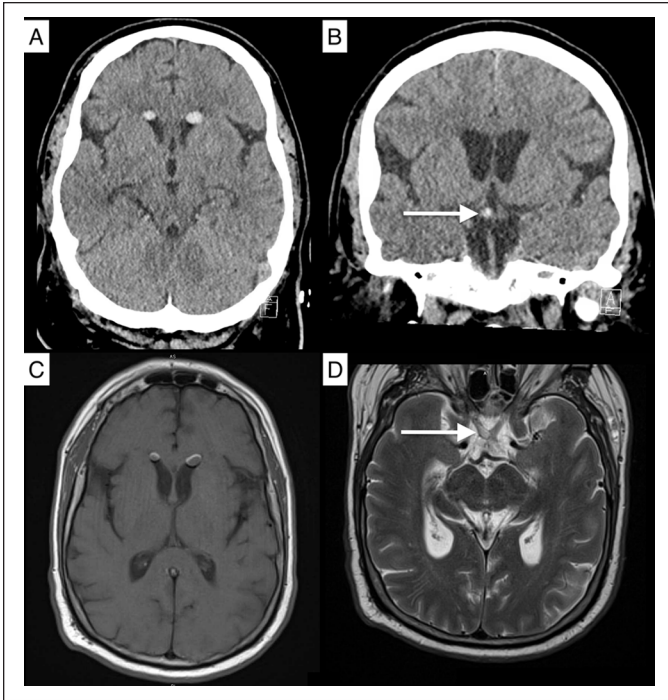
Neuroimaging at index presentation, 31 months postoperatively. (A) Computed tomography of the brain in supine positioning with axial slices shows bilateral ovoid hyperdensities consistent with silicone oil (SO) migration to the anterior horns of both lateral ventricles, with an average density of 85 Hounsfield units. (B) Additional hyperdensities are found in the right side of the optic chiasm. There is no evidence of hydrocephalus, cerebrospinal fluid outflow obstruction, or intracranial mass effect. (C) Magnetic resonance imaging (MRI) of the brain with gadolinium contrast in supine positioning. Axial slices in the T1-weighted sequence show well-circumscribed ovoid structures of intermediate signal in the anterior horns of both lateral ventricles. The right-sided lesion measures 4.7×4.6 mm axially. The left-sided lesion measures 5.8×9 mm axially. (D) Noncontrast T2-weighted MRI shows similar intensity lesions noted within the right optic nerve with obliteration of the subarachnoid space sheath and the right half of the optic chiasm. Features of bilateral embolic stroke are also present and are of uncertain relationship to SO migration.
